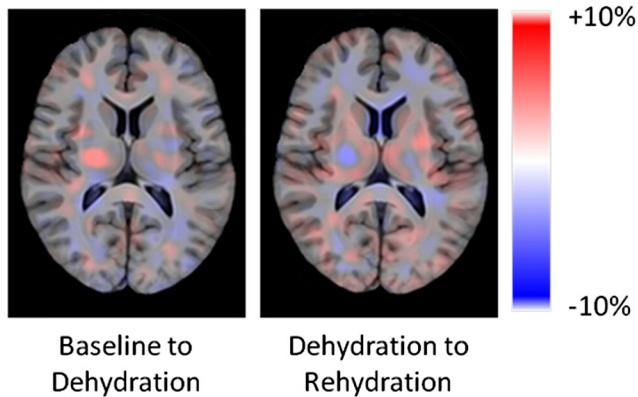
(a) Example raw and pT2 images. From left to right: PD-weighted scan, T2-weighted scan, T1-weighted scan, and pT2 (pseudo-T2) map within the brain mask from one subject. Each row represents epoch (baseline, dehydrated, and rehydrated) where the images are not registered but chosen for similar slices. (b) The Jacobian maps averaged from all subjects, smoothed with an 8 mm-FWHM, and overlaid on the study-specific template.
